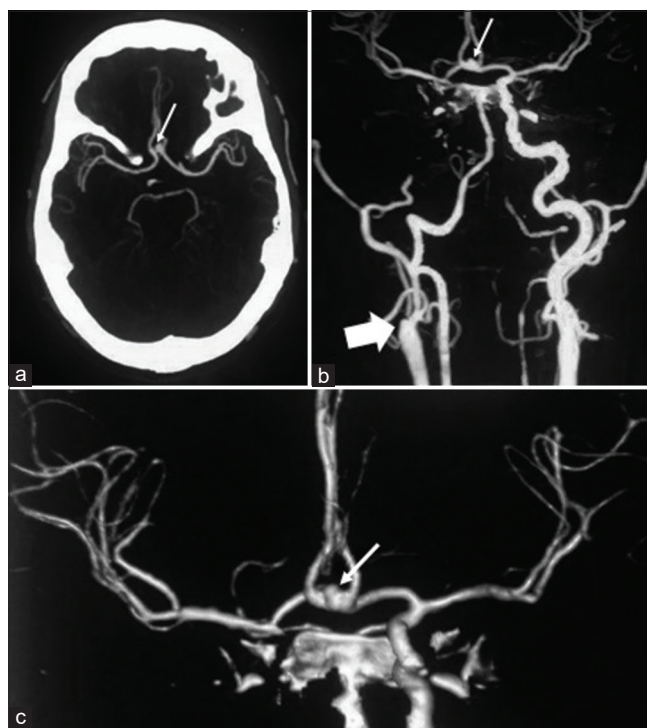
Computed tomography angiogram (CTA) (a) and 3D-reconstructed CTA (b and c) showing a left A1-ACoA junction aneurysm with right superior-anterior projection (thin arrows). The right internal carotid artery (ICA) is not visualized down to its origin from the common carotid artery (thick arrow). The right anterior cerebral artery and middle cerebral artery are supplied by the left ICA through the left A1-ACoA pathway.
